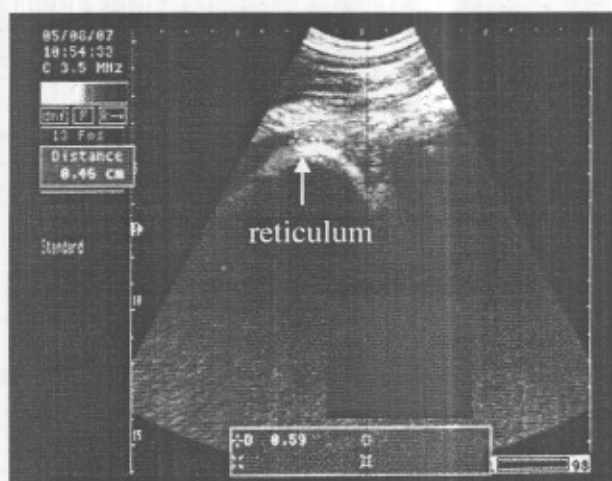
Ultrasonographic image of normal reticulum which appear as a half-moon-shape structure with a smooth contour. Using 3.5 MHz sector probe.
